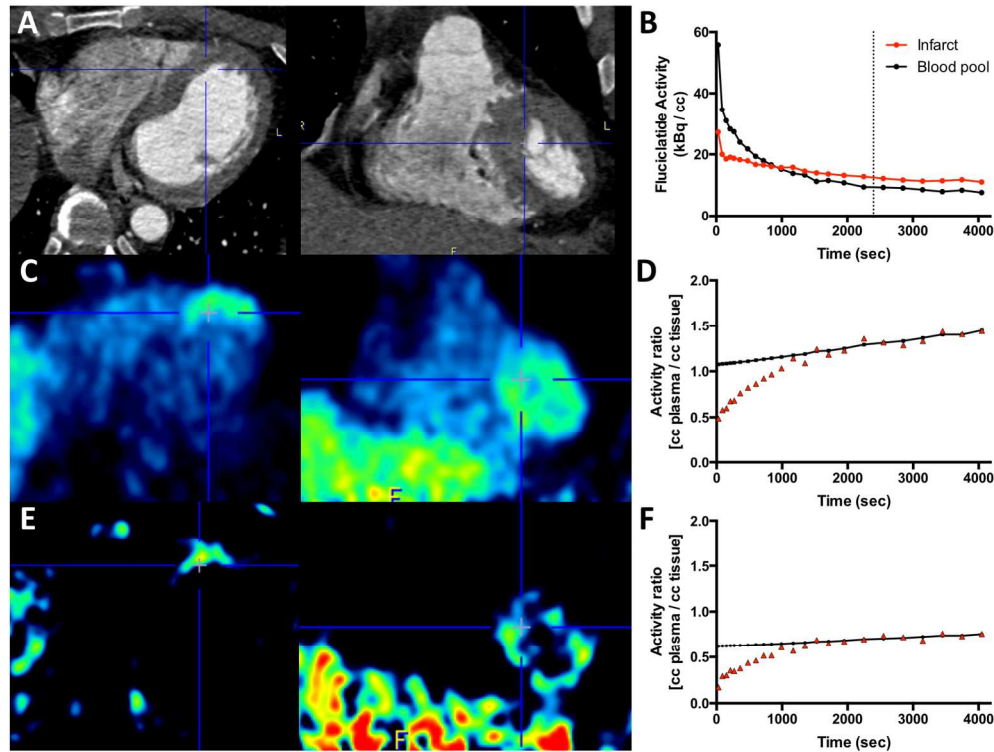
Dynamic Analysis of ^{18}F -Fluciclatide Uptake. Axial and sagittal CT angiography of the thorax in a patient with recent anterior MI (A). The time-activity curves generated from the descending aorta and the apical interventricular septum (blue crosshairs) show increased uptake in the infarct relative to blood pool. Optimal contrast between ^{18}F -fluciclatide tissue and blood pool activity was observed after 40 min (dotted line, B). The PET image in the axial and sagittal plane shows increased uptake within the apical septum, although there is some background activity (C). Patlak analysis of ROI's placed in the interventricular septum confirms integrin binding, as evidenced by the gradient of the slope and the y-intercept (D), and using a K_i -generated image we can better identify and delineate focal uptake within myocardium (E). A region of remote myocardium within the same patient generates a Patlak curve with significantly lower gradient and intercept in comparison (F).
